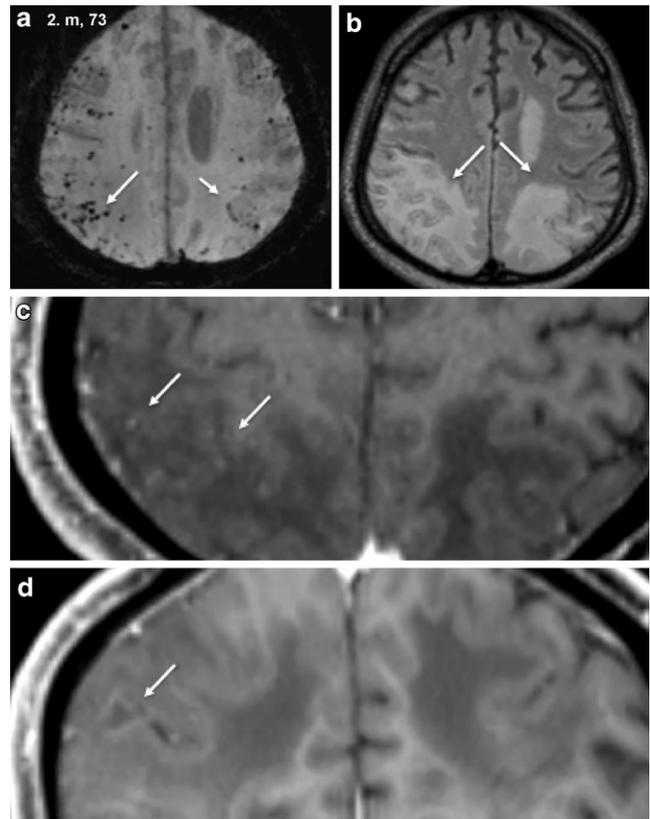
73-year-old man with CAA-related inflammation (case 2). Axial susceptibility-weighted (a) imaging with multiple bilateral cortical-subcortical microbleeds (*white arrows*), axial FLAIR (b) imaging with bi-parietal subcortical oedema with U-fiber involvement (*white arrows*), axial (c) and coronal (d) contrast-enhanced spin-echo T1-weighted images with faint leptomeningeal contrast enhancement (*white arrows*)
